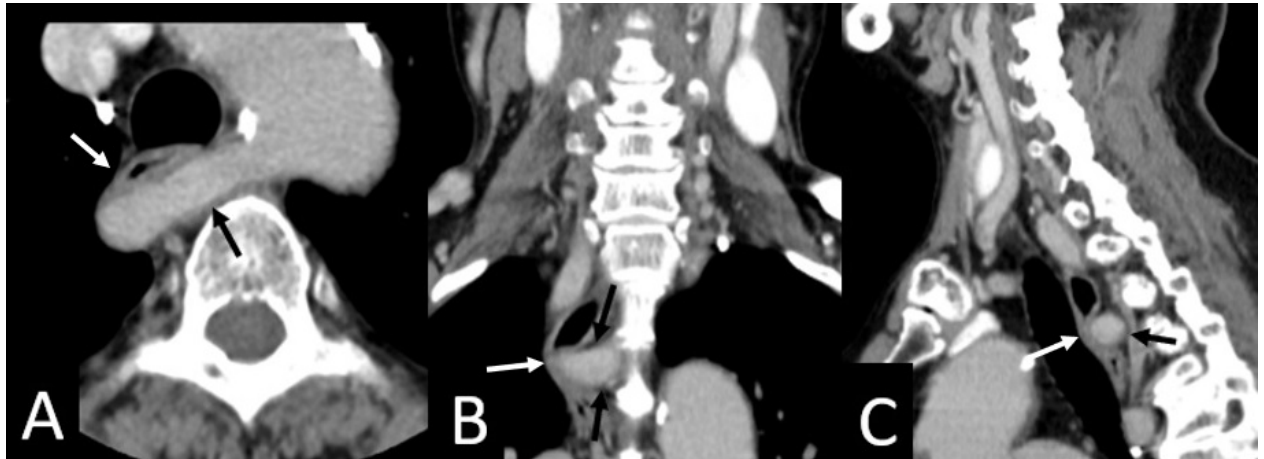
Contrast-Enhanced CT Neck Contrast-enhanced CT of the neck showed an anomalous right subclavian artery (black arrows), resulting in rightward displacement and extrinsic compression of the cervical esophagus (white arrows). A, axial view; B, coronal view; and C, sagittal view.
